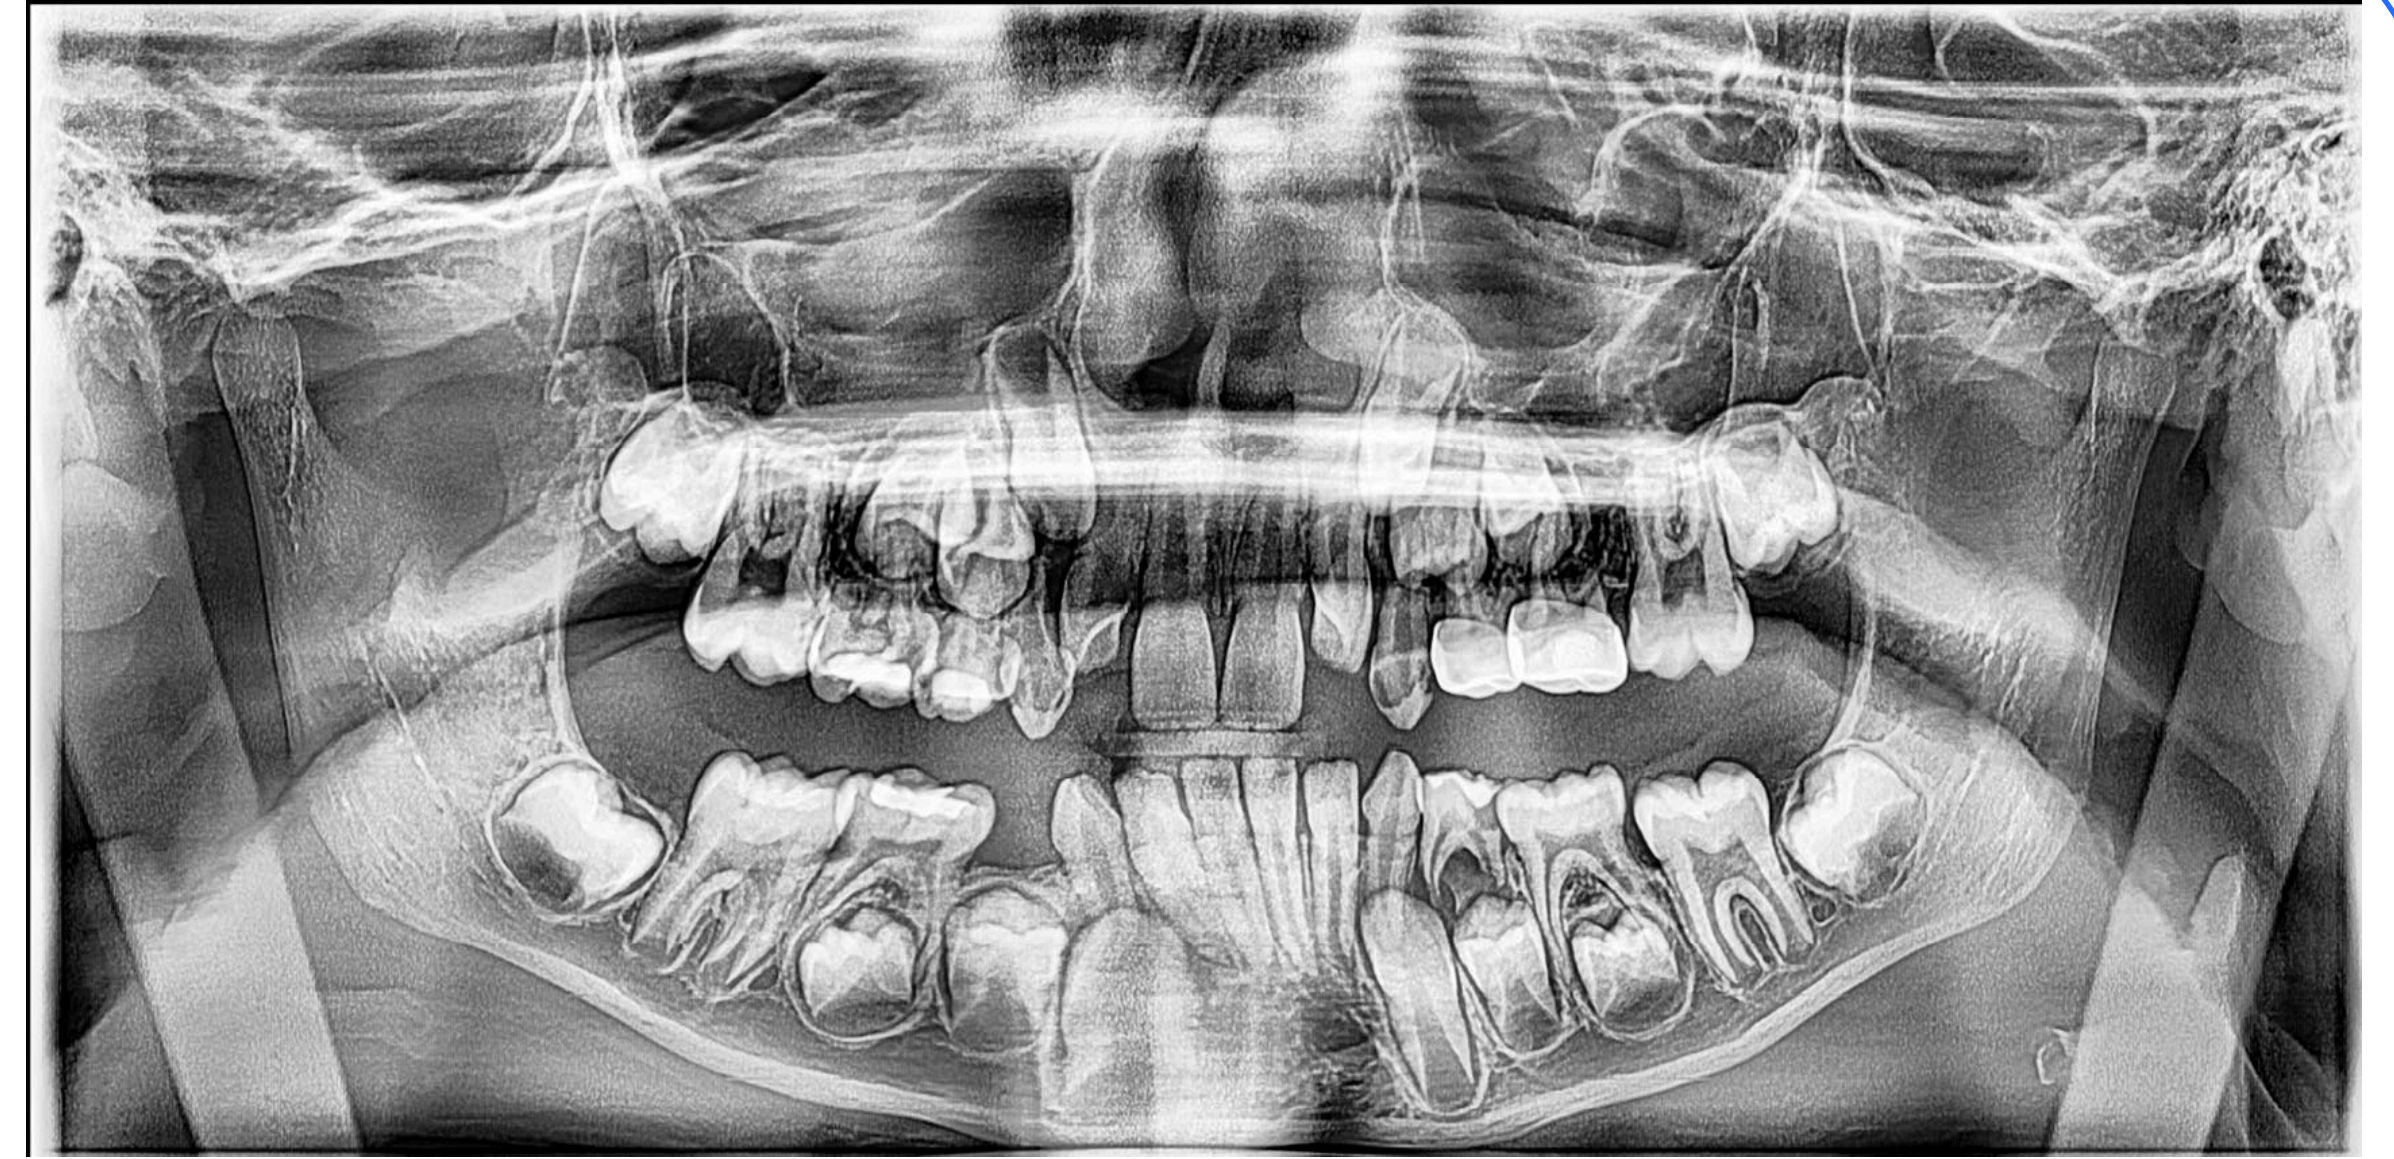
Panoramic radiograph: This panoramic displays unerupted #7, #10, and #19 as well as crowding due to patient micrognathia. Note: Dental care presented on image was provided previously in 2018.
